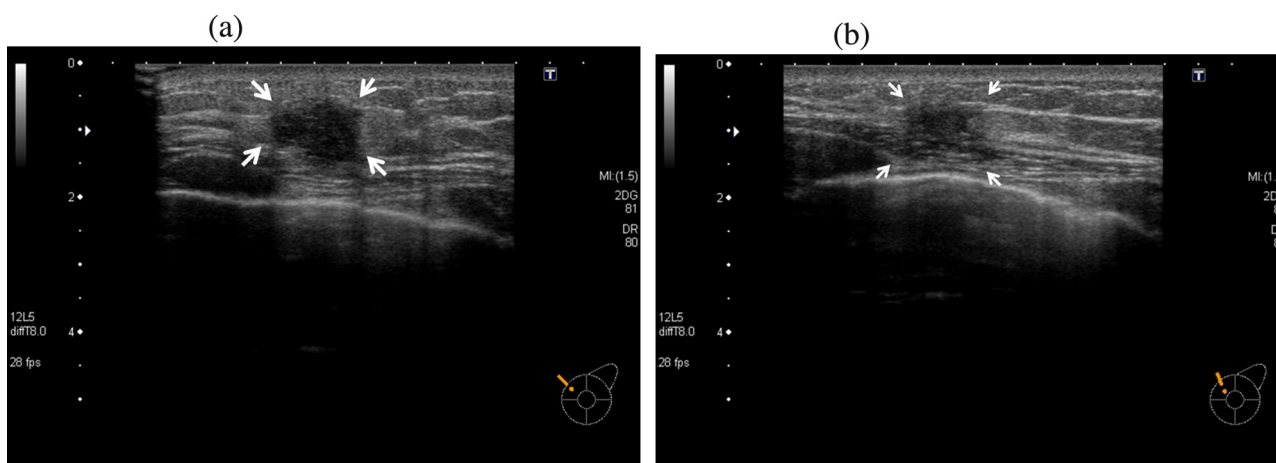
(a) Ultrasonography at the initial diagnosis. A morphologically irregular (13 × 9 × 12 mm) and sharply demarcated hypoechoic mass with a rough surface and internal heterogeneity was found in the left upper-inner quadrant (arrow). Posterior ultrasonography was unchanged. There was no lateral shadow. A hyperechoic area was observed in the tumor border. A papillotubular carcinoma with scirrhous invasion was suspected. (b) Ultrasonography immediately before surgery. The identified mass had reduced to 10 × 7 × 4 mm (arrow).
